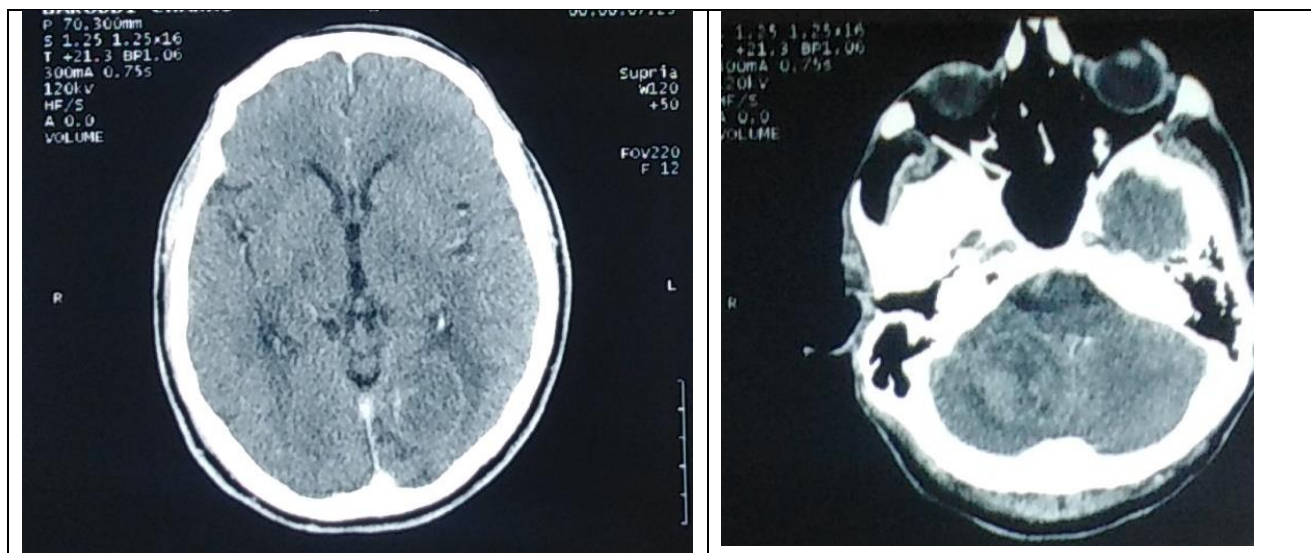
Axial cerebral CT- scan findings in a 55-year-old male with cerebral metastasis of the left occipital cerebral hemisphere and in the right cerebellum hemisphere.
